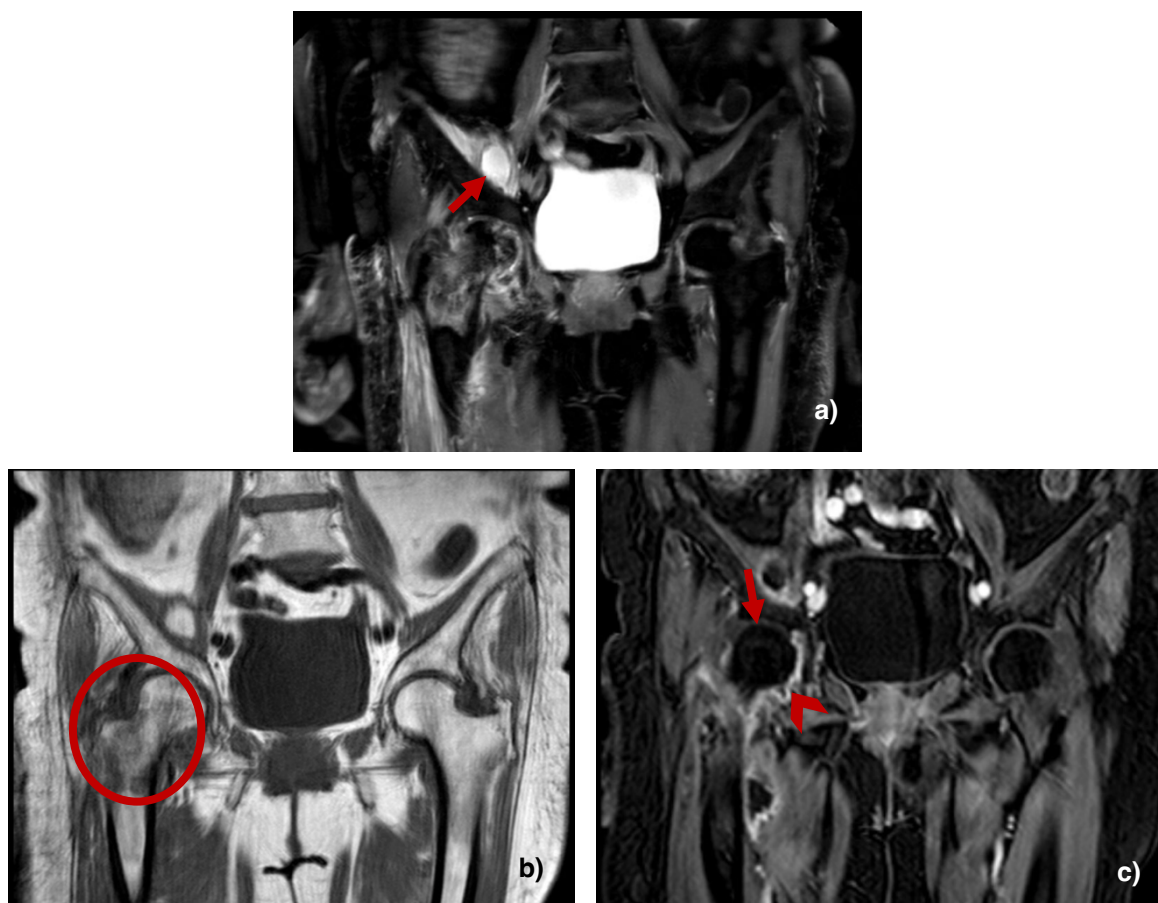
Pelvic MRI: a) Collection located within the right iliacus muscle, in close relation to the distal iliopsoas tendon (arrow) with marked hyperintensity on fluid-sensitive sequences, suggestive of abscess formation. b) Osteomyelitis at the right proximal femur. c) Septic arthritis of the right hip with low signal intensity (arrow) of the right femoral head compared with the contralateral femoral head and enhancement of the synovial membrane (arrowhead) around the right hip joint.
